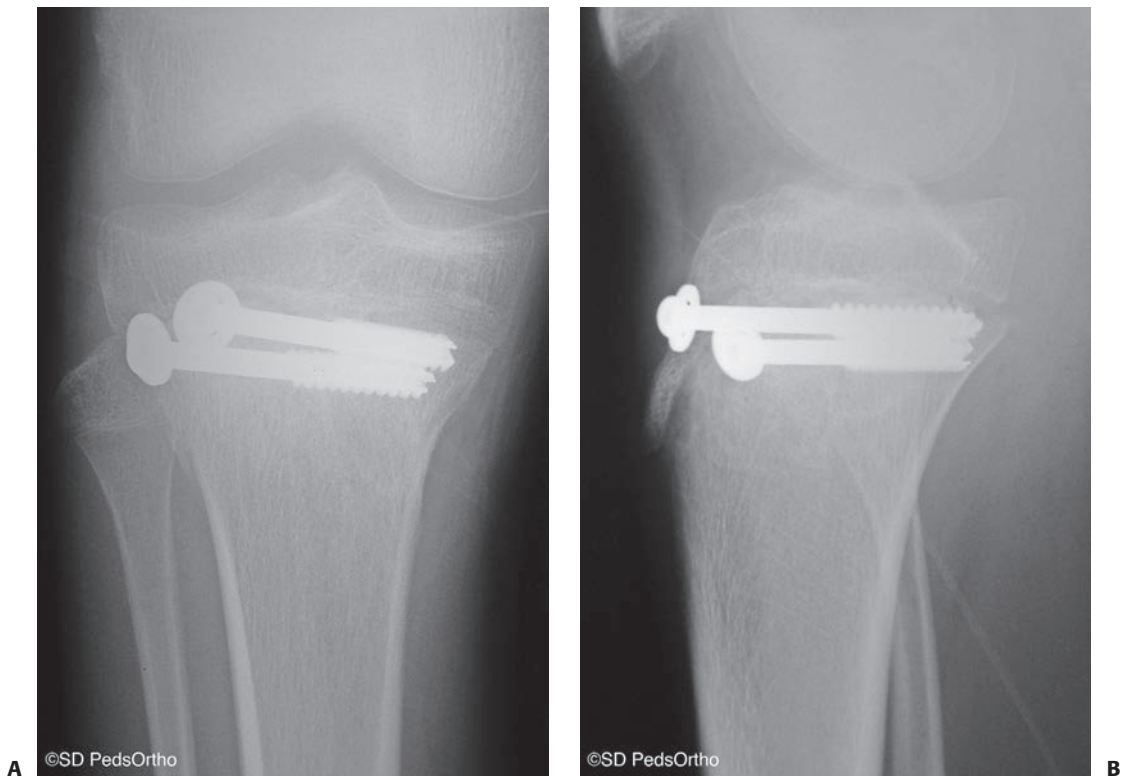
Salter–Harris type 2 proximal tibial physis fracture with two cannulated, partially threaded cancellous screws in the Thurston–Holland fragment. A: AP radiograph; (B) lateral radiograph.
